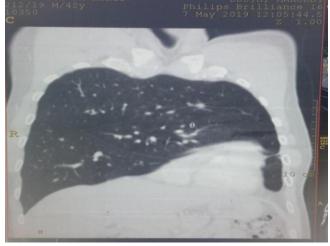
Coronary CT: Compensatory hypertrophy of the right lung with herniation into the left chest and mediastinal shift.
